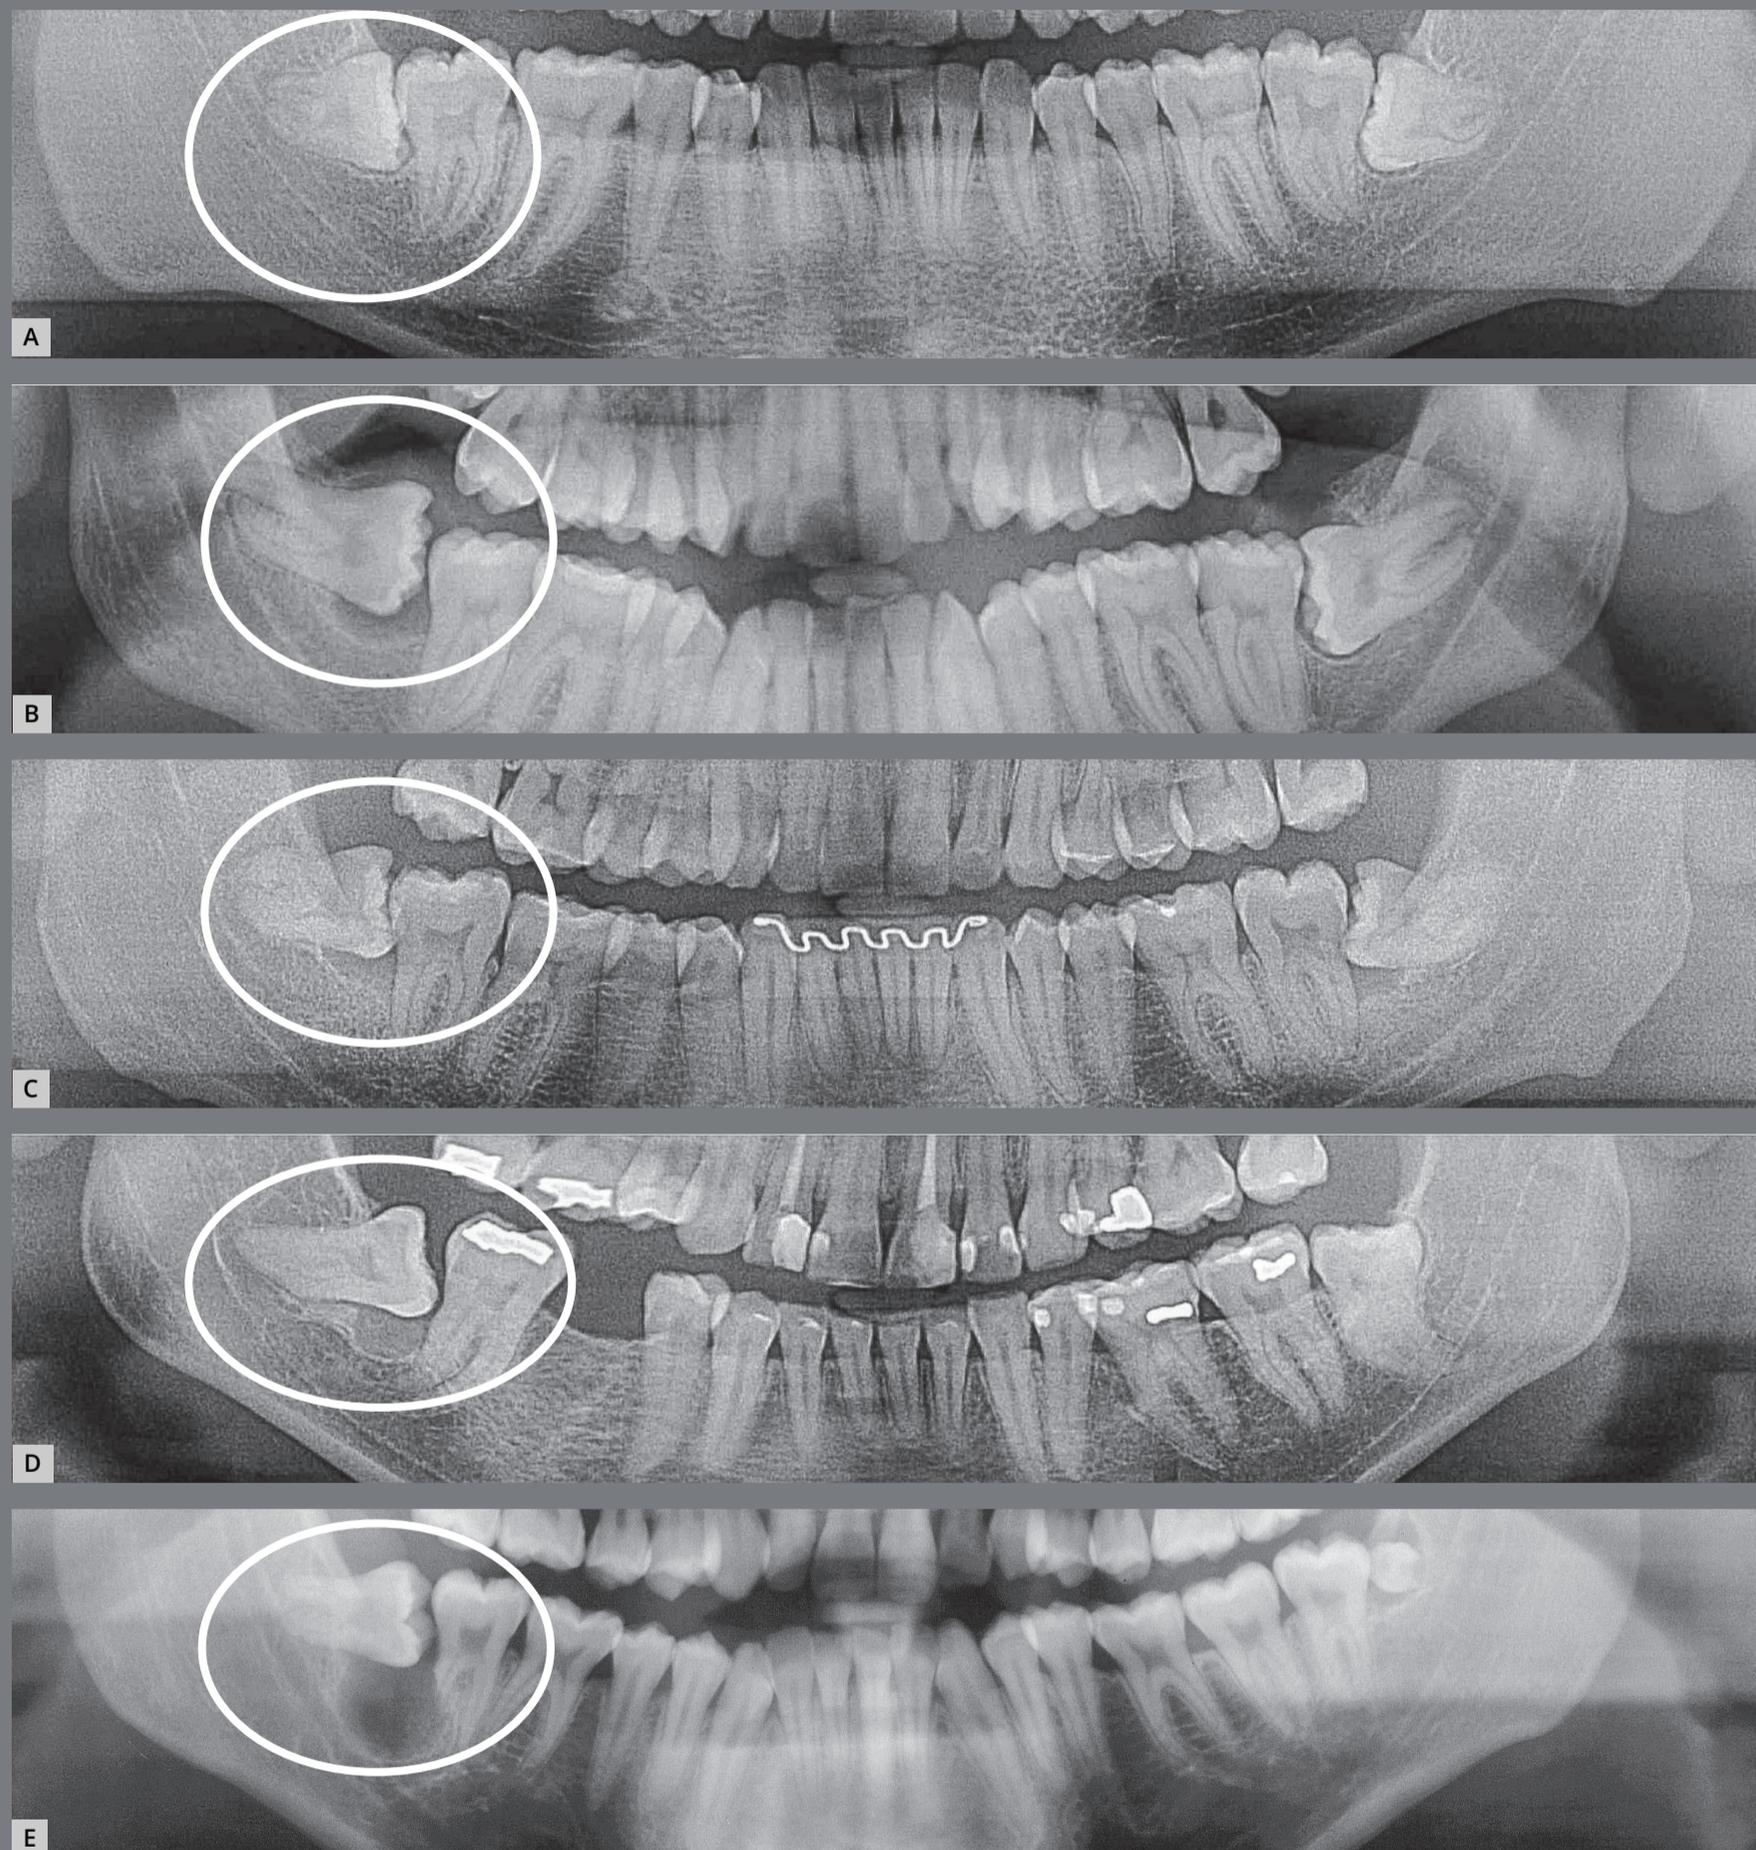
Paradental cysts from normal pericoronal space to the development on the mesial surface of the partially erupted lower third molars, mesially angulated and horizontalized on the right side of the panoramic radiographs. It is noteworthy that the patient in C was discharged from previous orthodontic treatment and was also affected on the left side.
